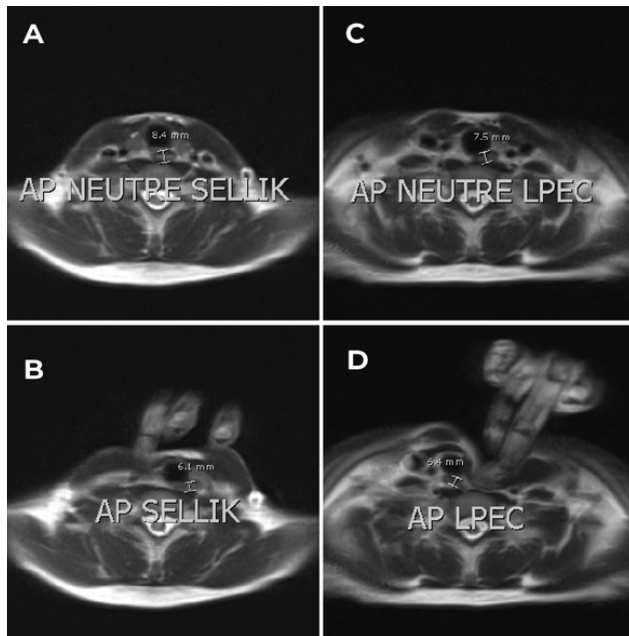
MRI images show: (A) the esophagus position without any compression and (B) when applying the cricoid pressure; (C) the esophagus position without any compression and (D) when applying the LPEC maneuver.
